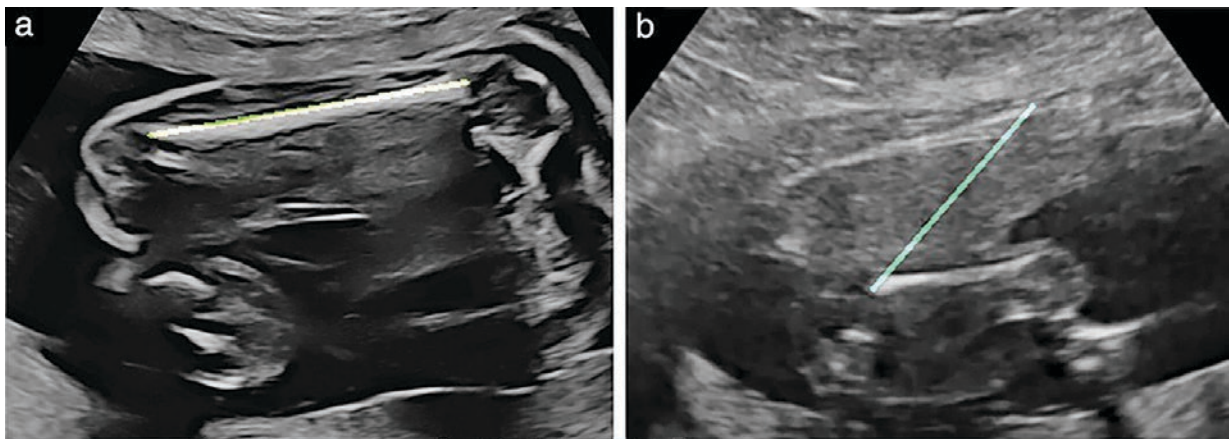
Grayscale ultrasound images labeled with real-time results from an AI model trained to detect and measure femur length
